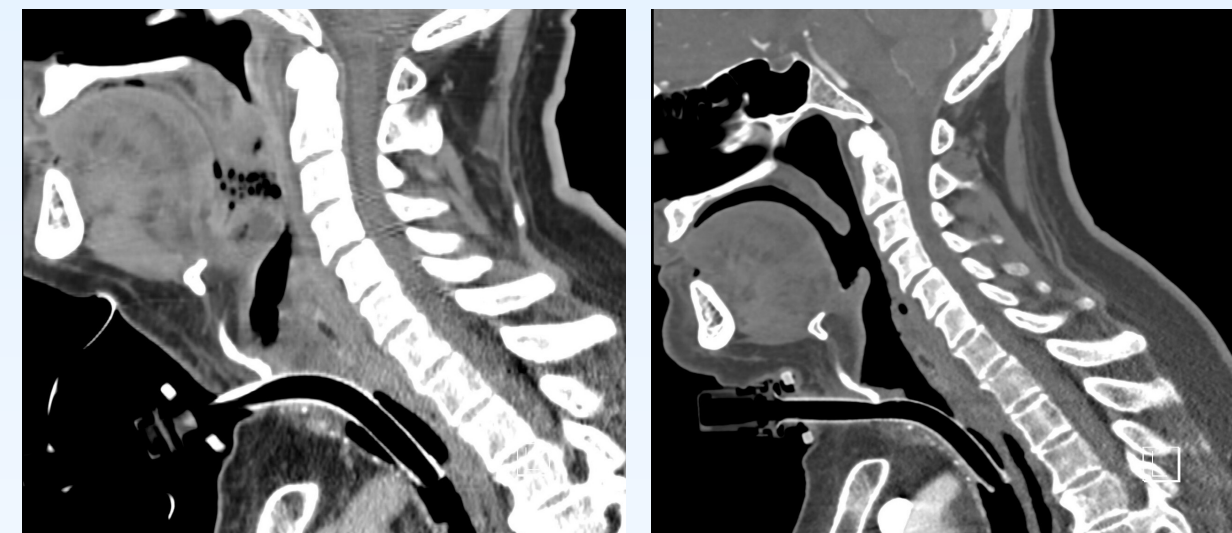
(A) Computed tomography scan of the neck with intravenous contrast in the sagittal plane on POD 0 showing irregular, diffuse mucosal thickening extending from the nasopharynx to the hypopharynx and supraglottic larynx causing a near complete airway obstruction. (B) Repeat CT of the neck with contrast in the sagittal plane on POD 15. Previously seen irregular thickening has decreased considerably and airway effacement has resolved.
